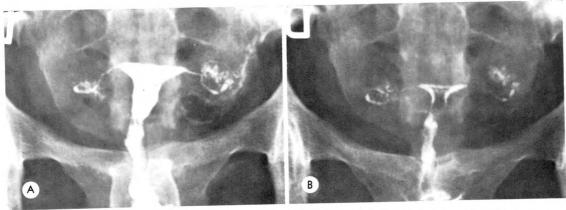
(A and B) Tuberculous salpingitis. (B) The pathologic salpingitic pattern is evident in the postvoiding roentgenogram.
